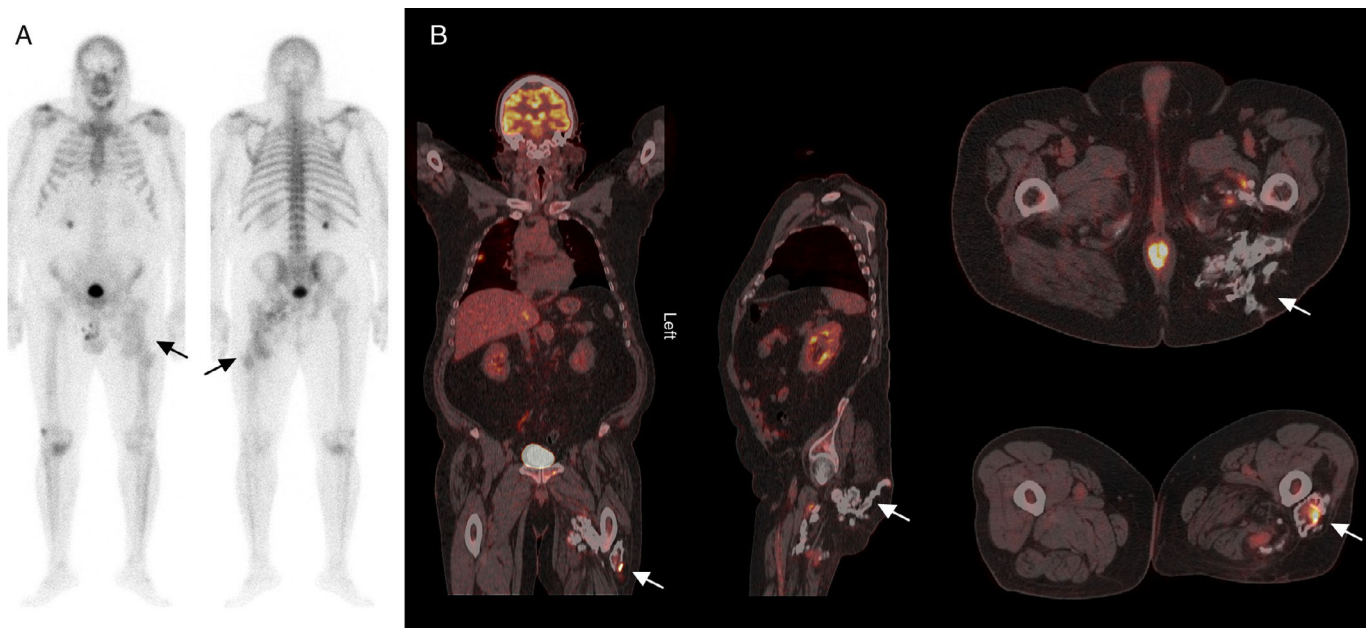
(A) Whole body bone scan with ^{99m}Tc -hydroxymethylene-diphosphonate in anterior and posterior projections that show a pathological and irregular increase in osteoblastic activity in the middle and proximal thirds of left thigh, with tracer uptake in adjacent soft tissues and a change in the normal bone morphology (arrows). (B) Coronal, sagittal and axial images of the ^{18}F -fluorodeoxyglucose positron emission tomography/computed tomography study showing multiple abnormal accumulations of the radiotracer that are distributed from posteroinferior planes of the left buttock up to the middle third of the ipsilateral thigh (arrows).
